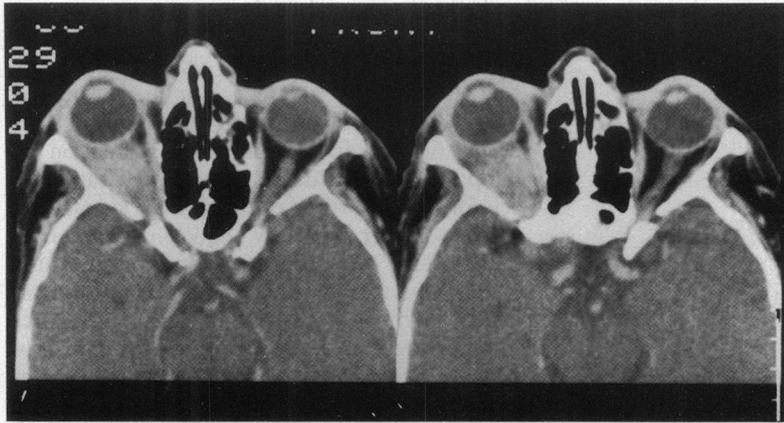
Reactive lymphoid hyperplasia of the right orbit: CT as in Figure 1. The radiographic density of the mass lesion is more inhomogeneous, although the variability is not marked.
